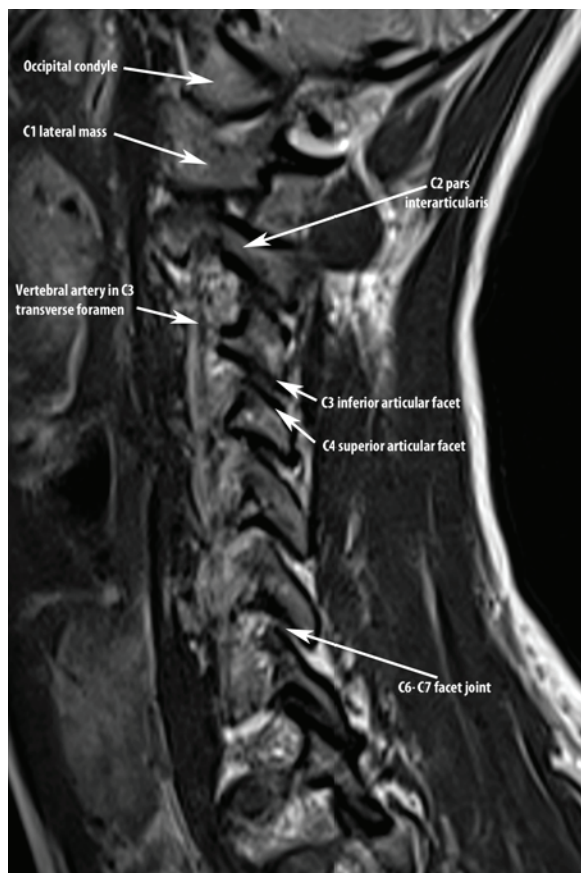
A sagittal T2-weighted paramidline image of the cervical spine shows the vertebral artery in long axis coursing through the transverse foramina of the cervical spine. The facet joints are most easily evaluated in the parasagittal plane, as shown here.[†]
